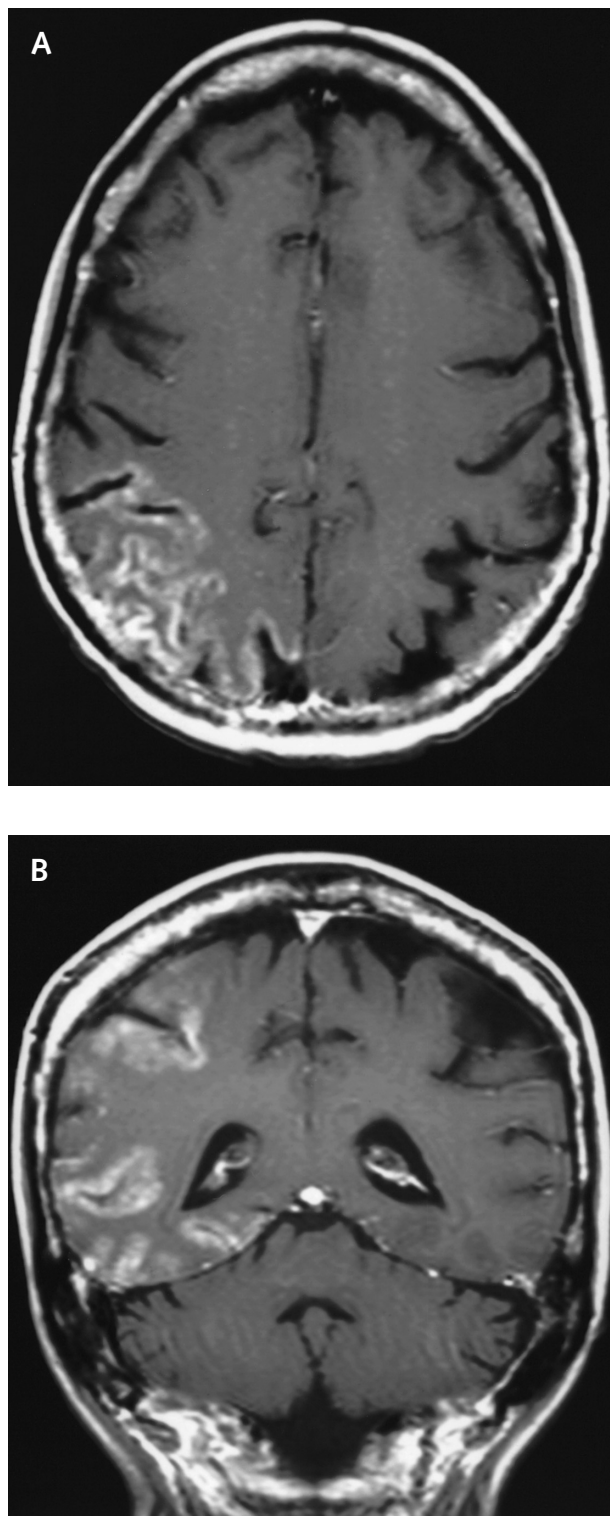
Patient 1—MRI brain scan 6 days post-ictus. Axial (A) and coronal (B) T1-weighted images of the brain following intravenous administration of gadolinium. Gyriform enhancement of right posterior temporo-parieto-occipital cortex.
